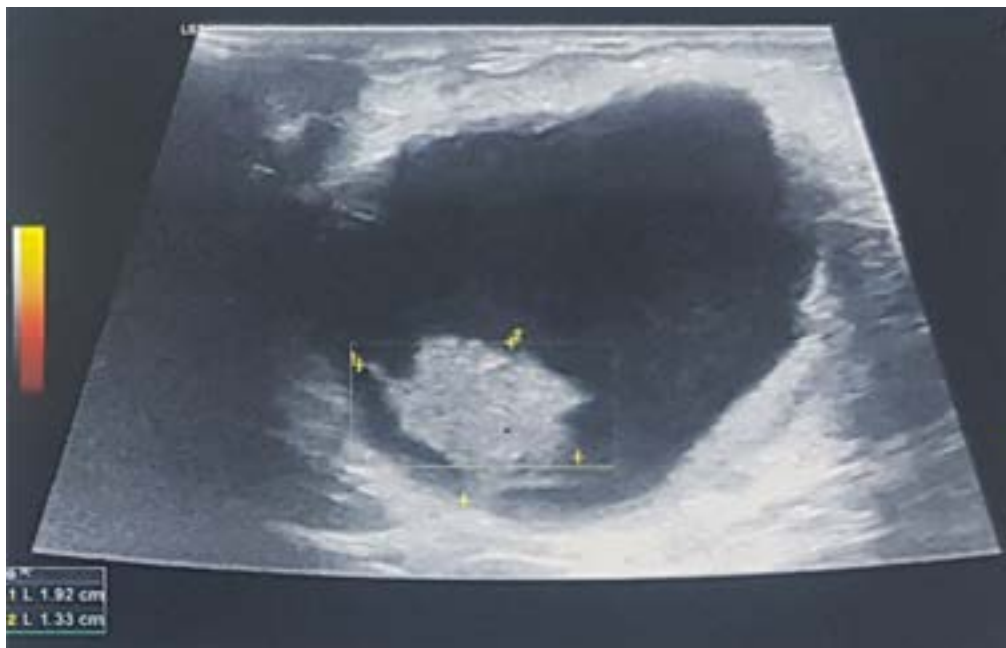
Ultrasound image of a complex cystic mass lesion
